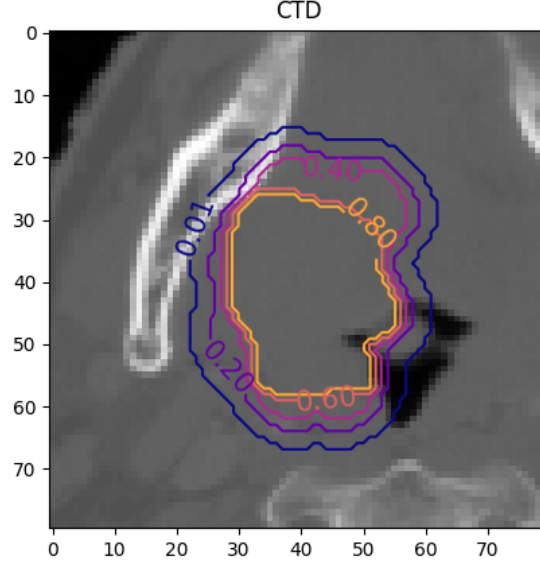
CTD expansion of the GTV for the considered CT.
